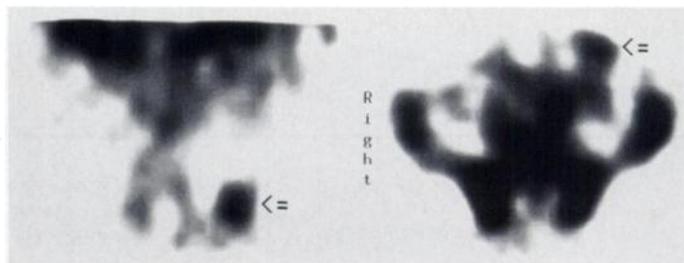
Recurrent rectal adenocarcinoma (arrow) visualized by ^{111}In -CYT-103 and ^{123}I -VIP (Table 5, Patient 8). Upper panel: The ^{111}In -CYT-103 scan (SPECT reconstruction; left: coronal slice; right: transverse slice) indicated the tumor recurrence at the resection site at 48 hr (images) and at 72 hr (not shown) after injection. Lower panel: ^{123}I -VIP planar imaging of the abdomen in anterior view showing the corresponding lesion indicating the recurrent tumor.
